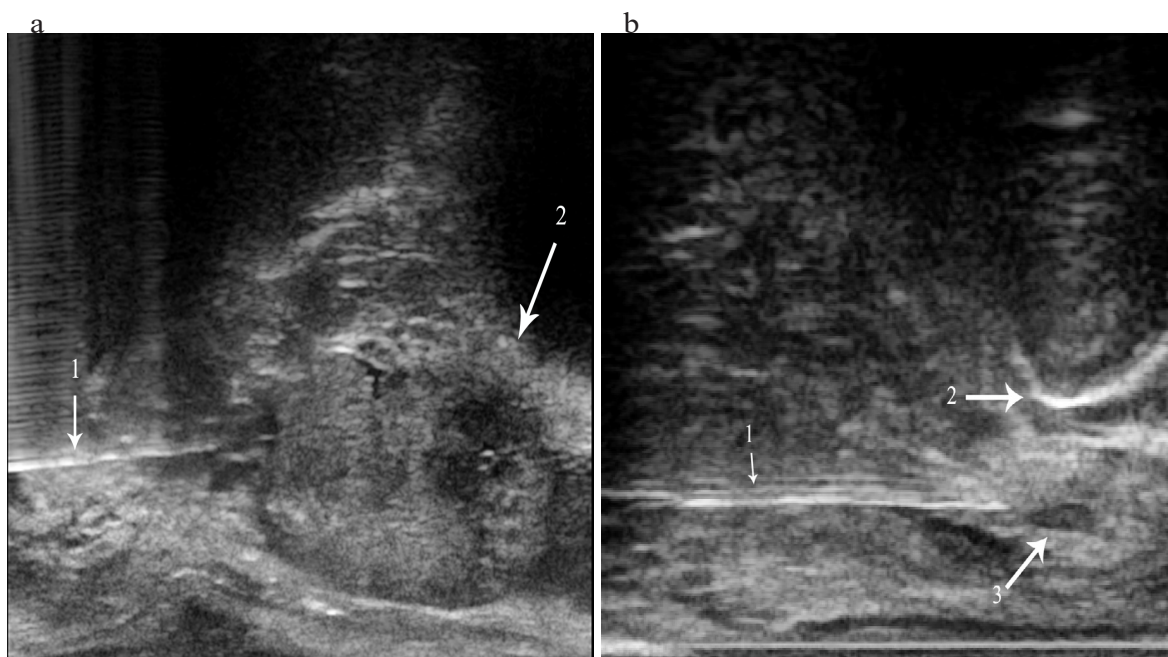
(a) Transrectal ultrasound guided BTX-A injection around the prostate. Arrow 1: needle; arrow 2: residual prostate; (b) Transrectal ultrasound guided pelvic floor muscle injection with BTX-A. Arrow 1: needle; arrow 2: ischiopubic ramus; arrow 3: levator ani muscle
